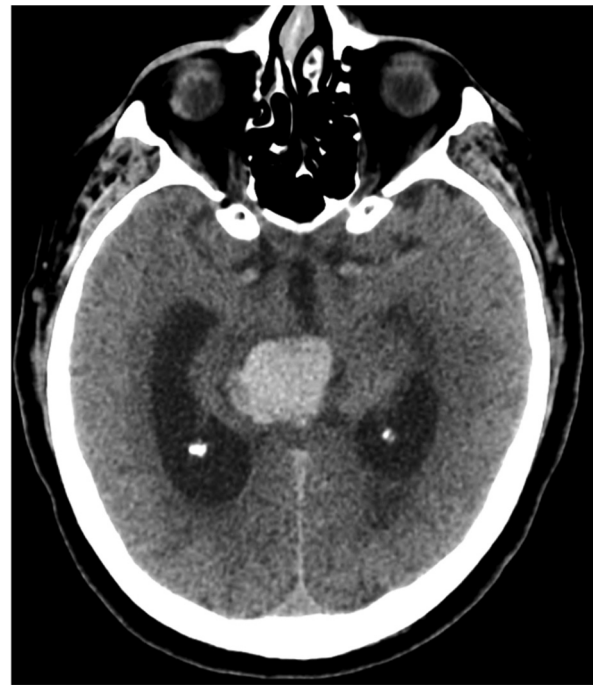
Axial non-contrast CT image showing enlarged 2.1 × 2.6 × 3.4 cm hemorrhage extending into the medial inferior aspect of the thalamus.
